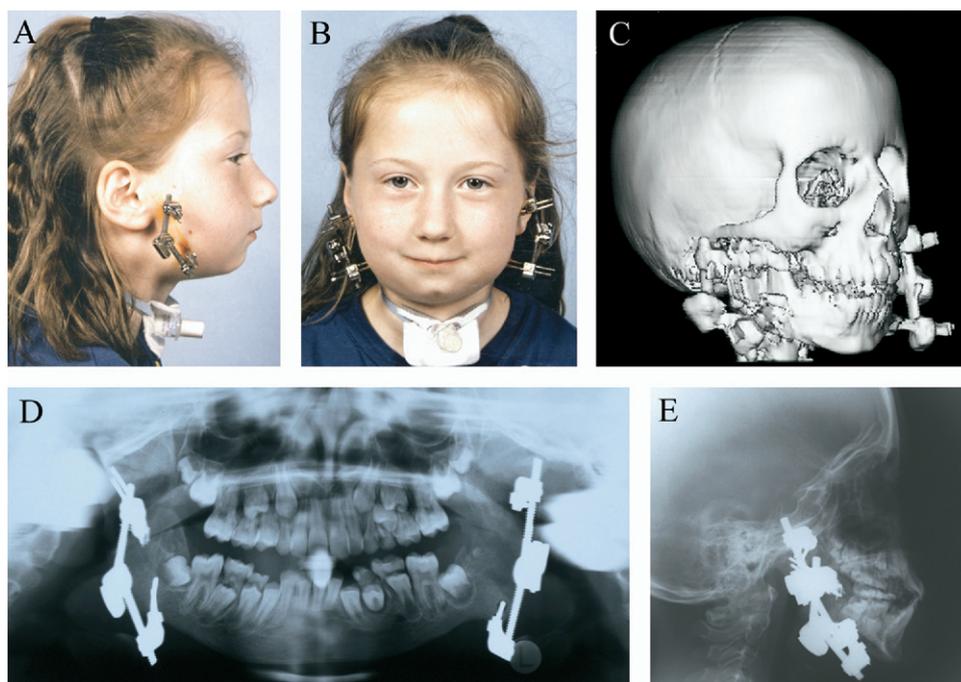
Prestabilization records at 9 years 7 months: A and B, facial photographs; C, 3-dimensional computed tomography scan; D, panoramic radiograph; E, cephalometric radiograph.
